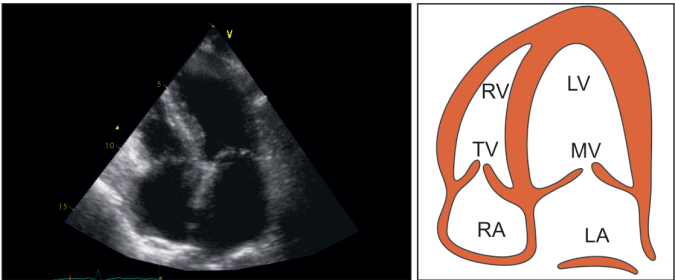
Apical 4-chamber (A4CH) view
